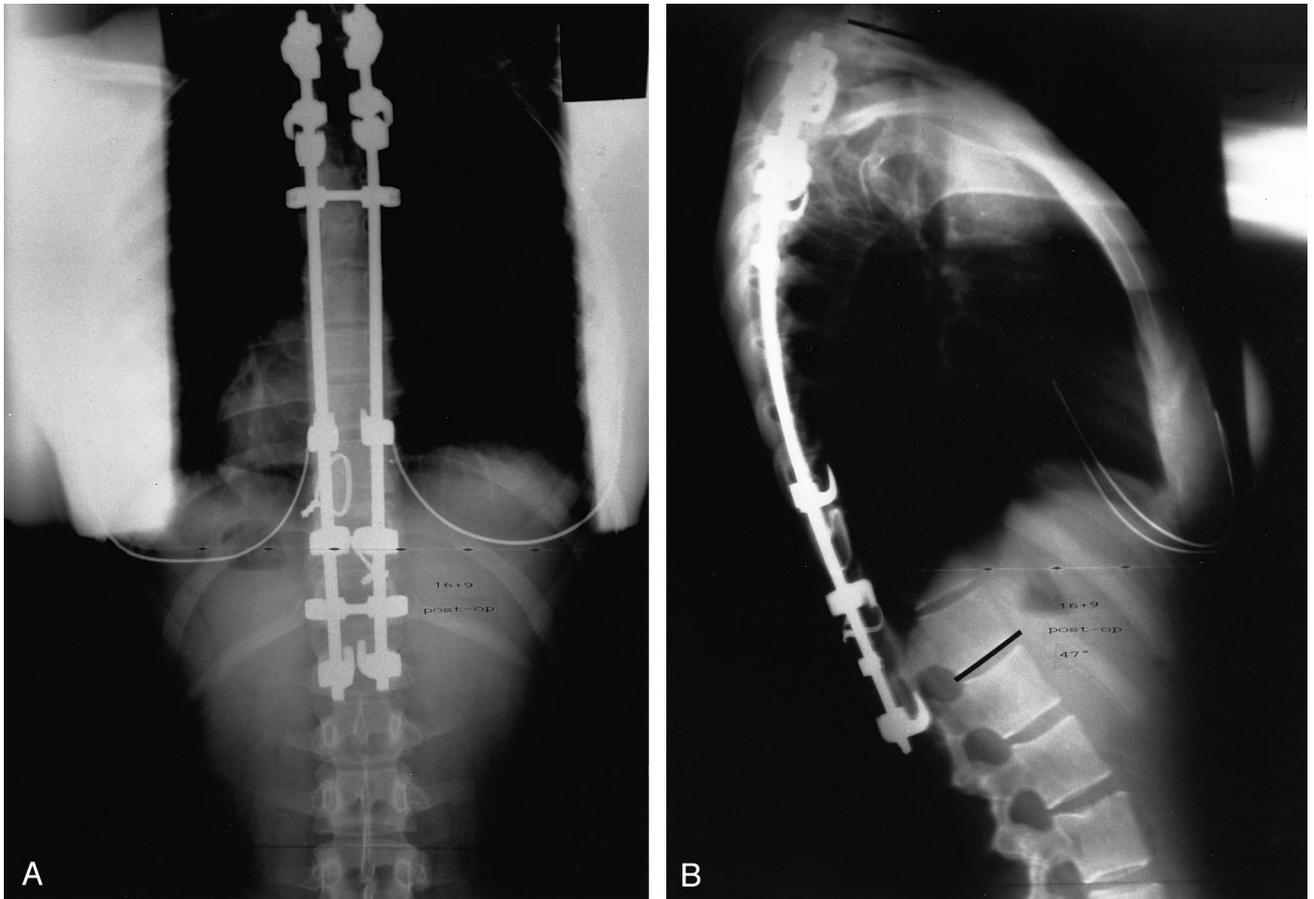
A, Postoperative PA radiograph of the spine following corrective instrumentation and fusion. B, Postoperative lateral radiograph following anterior disc excision and fusion via thoracoscopic approach and posterior CD horizon spinal instrumentation and fusion. The curve has been reduced to 47°. PA = postero-anterior.
